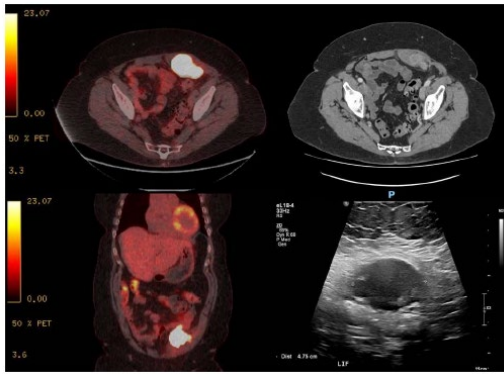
Ass in the left rectus sheath (top left = axial PET CT, bottom left = coronal PET CT, top right = axial contrast CT, bottom right = trans abdominal ultrasound).
